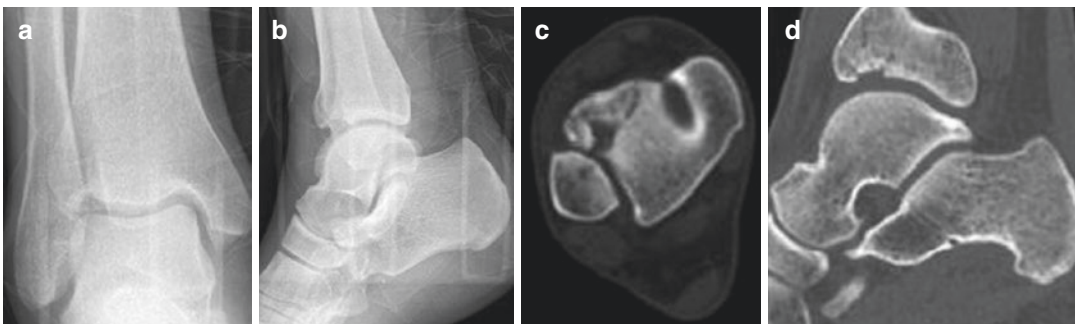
(a, b) Radiographs of a split depression type plafond fracture. (c, d) Axial and sagittal computed tomography images of the same patient
